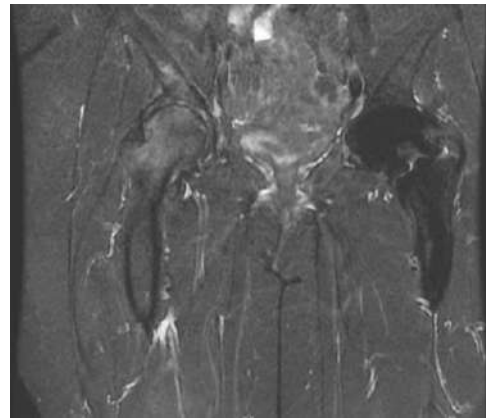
MRI of the right hip joint at 24 months post procedure (November 2022).
